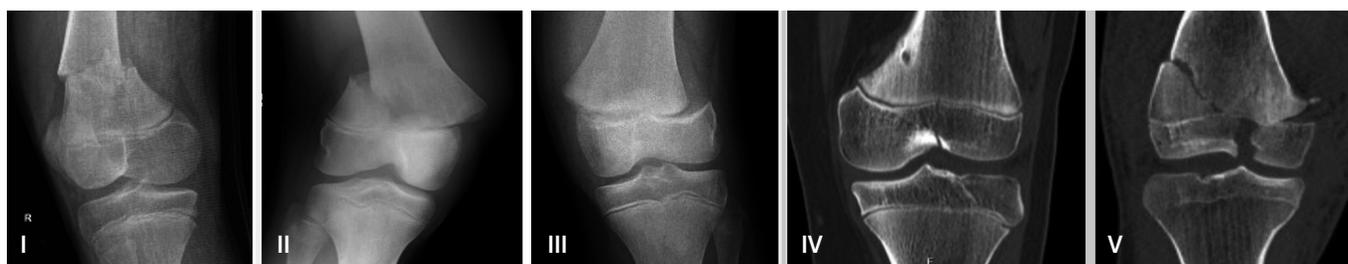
Demonstrative radiographs describing the Peterson fracture classification.
